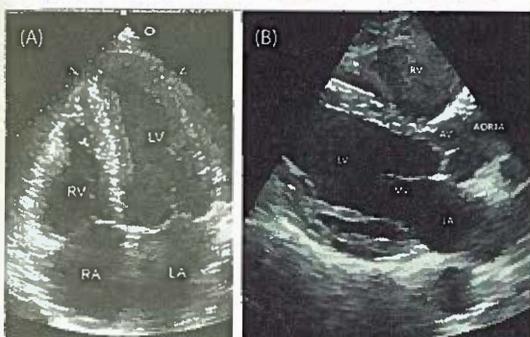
(A) Normal Echocardiography - Four Chamber View, (B) Normal Echocardiography - Parasternal Long Axis View
